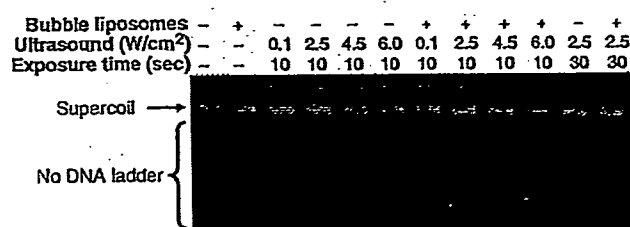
Plasmid pCMV-Luc exposed to ultrasound under various conditions with or without Bubble liposomes. After exposure to ultrasound, Bubble liposomes were removed using phenol/chloroform and then pCMV-Luc was conventionally precipitated with ethanol. The precipitate was dissolved in TE buffer and resolved by electrophoresis in 0.7% agarose gels.
